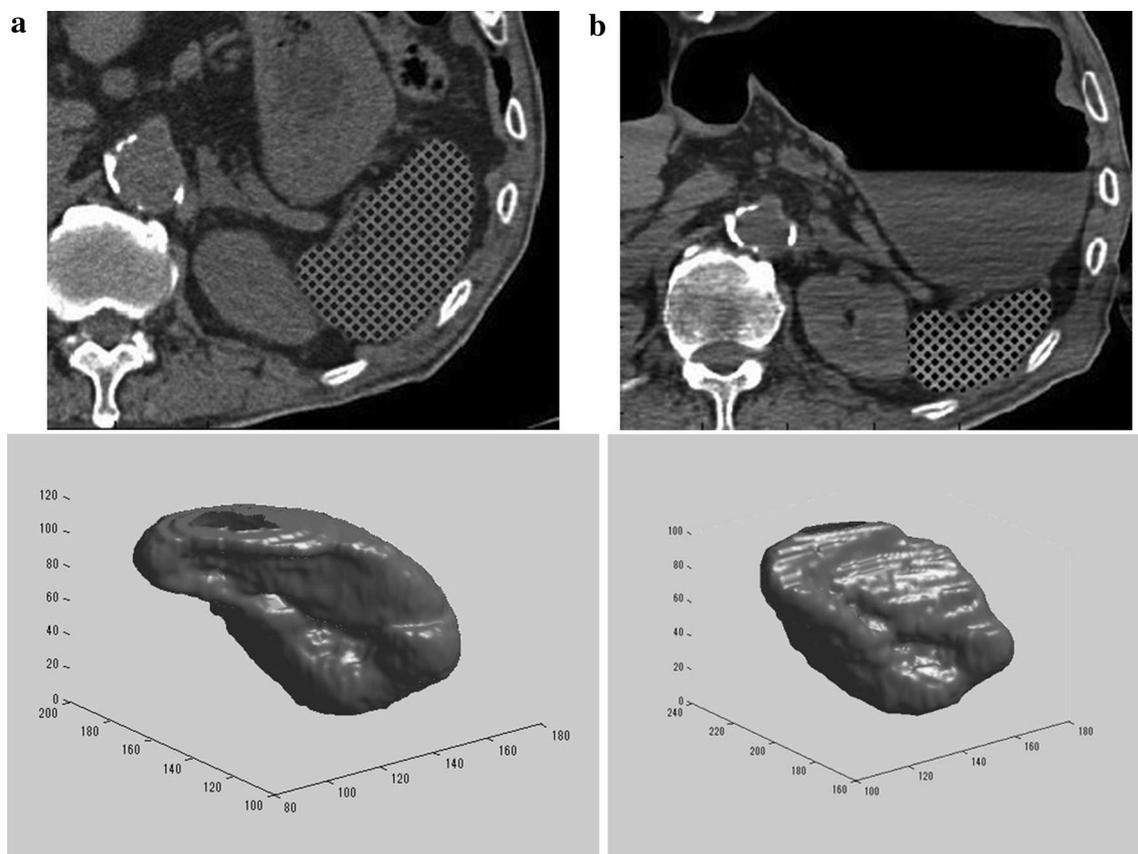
79-year-old male, who died from hematemesis. Splenic volume measurements and three-dimensional images on antemortem CT (a) and postmortem CT (b). The volumes of the spleen on antemortem and postmortem CT were 242.4 cm^3 and 112.1 cm^3 , respectively
